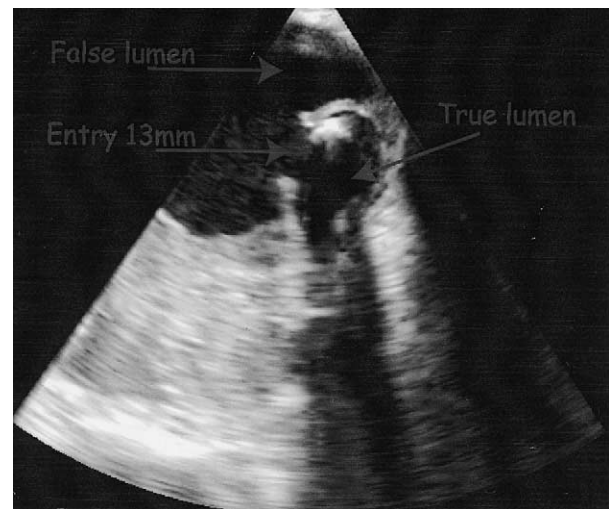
Transoesophageal echocardiography (TEE) showing the entry between the true and false lumen of the thoracic aorta in a patient with type B-dissection
